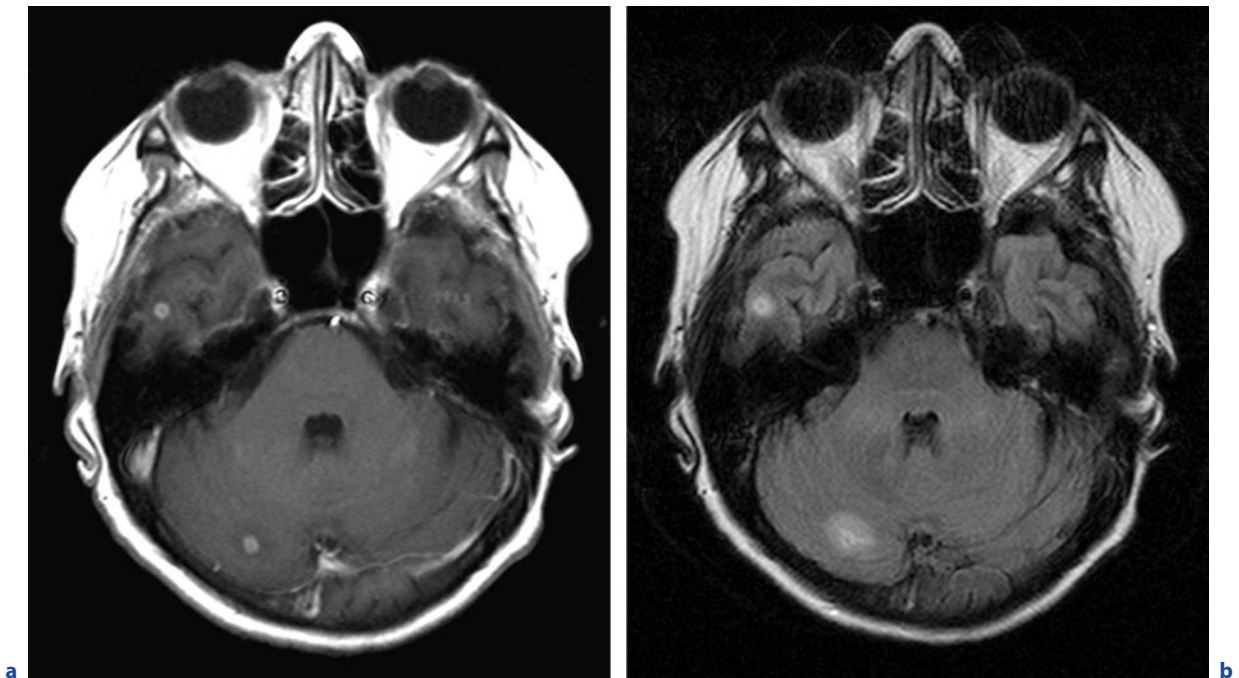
Brain abscesses due to *Nocardia* infection. A 60-year-old woman with amyloidosis who was immunocompromised after heart transplantation. a Axial T1-weighted images after contrast administration. b Axial FLAIR image. c,d see next page
